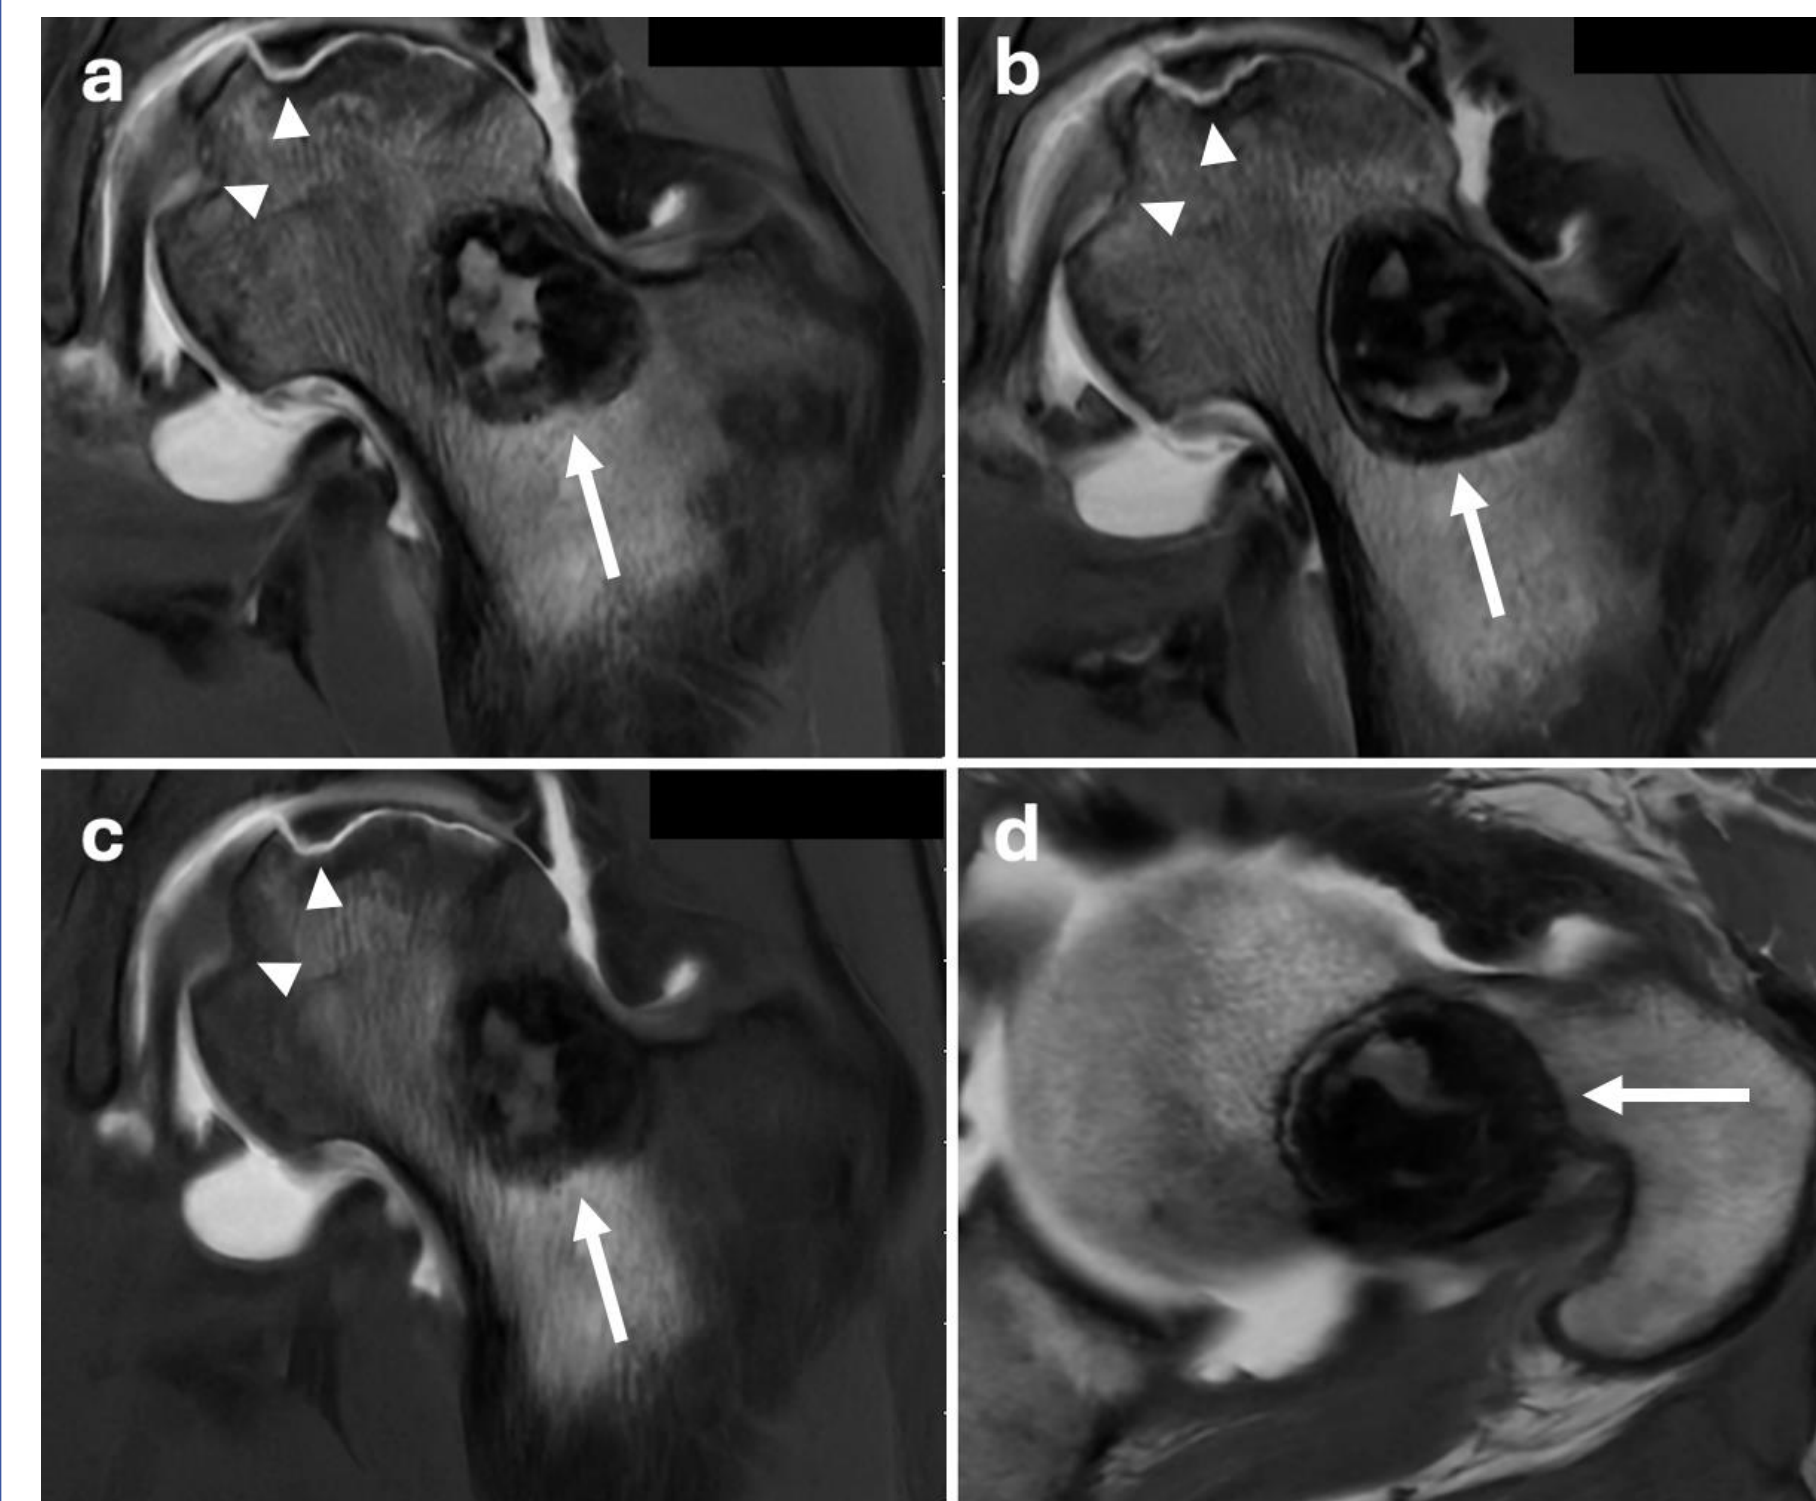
Coronal MRI images with proton density-weighted (a and b) and T1-weighted (c) sequences demonstrate avascular necrosis of the superior femoral head, with instability indicated by cortical breakthrough in the superior medial region, along with contrast-enhanced areas of necrosis (white arrowheads). Coronal proton density-weighted (a and b), T1-weighted (c), and axial T1-weighted (d) images show a well-circumscribed lesion in the left femoral neck, exhibiting mixed sclerotic and cystic characteristics without aggressive features, measuring 2.4 x 2.6 x 2.5 cm (white arrows).
